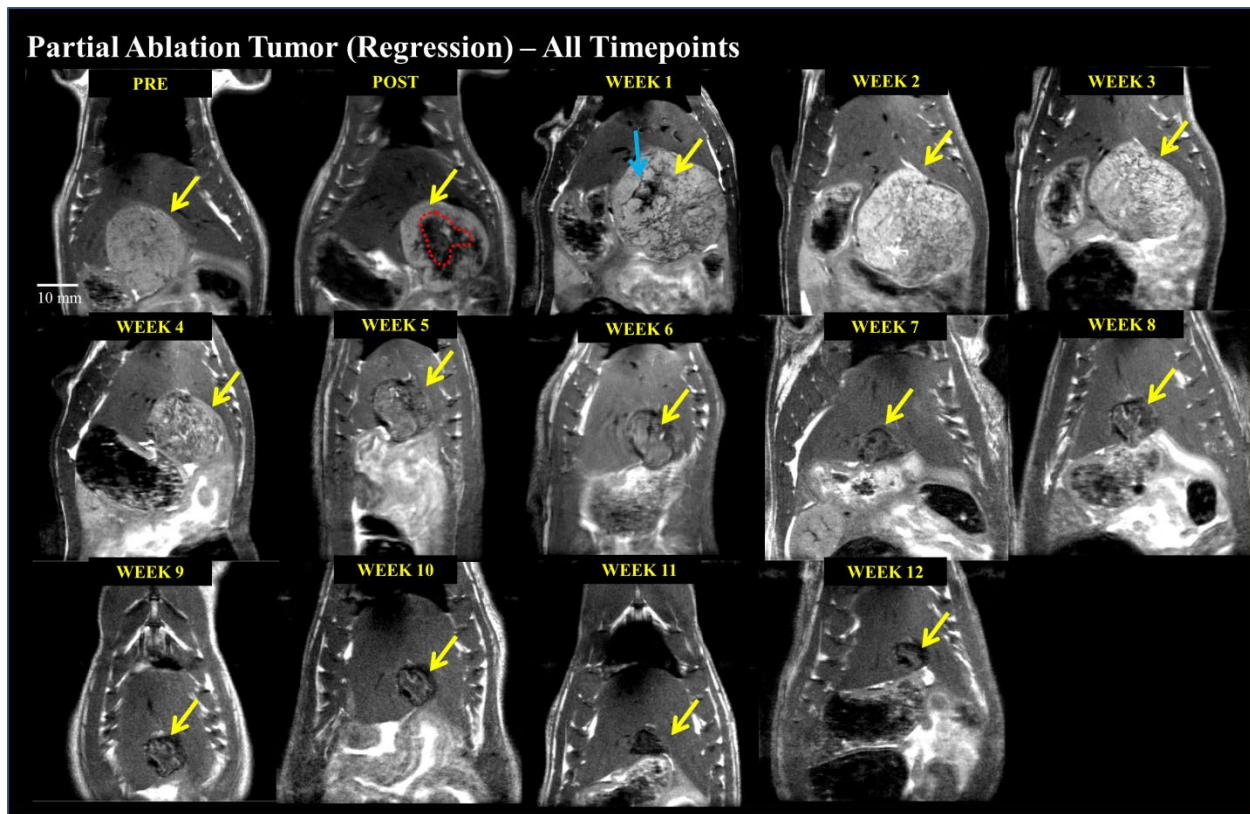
T2W MRI appearance of histotripsy treated tumor (partial ablation) at all timepoints. Partial ablation - pre-treatment (mildly hyperintense), post treatment ablation zone (hypointense, shown by red dashed lines) and untreated tumor region (mildly hyperintense), the lesion at week 1 (mildly hyperintense) with pseudoprogression characteristics (blue arrow), week 2 (mildly hyperintense), week 3 (mildly hyperintense, size regression), weeks 4-12 (gradual transformation to hypointense, size regression), and week 12 (~5 mm hypointense region). This figure demonstrates all imaging timepoints for the case demonstrated in Figure 4-4B.
